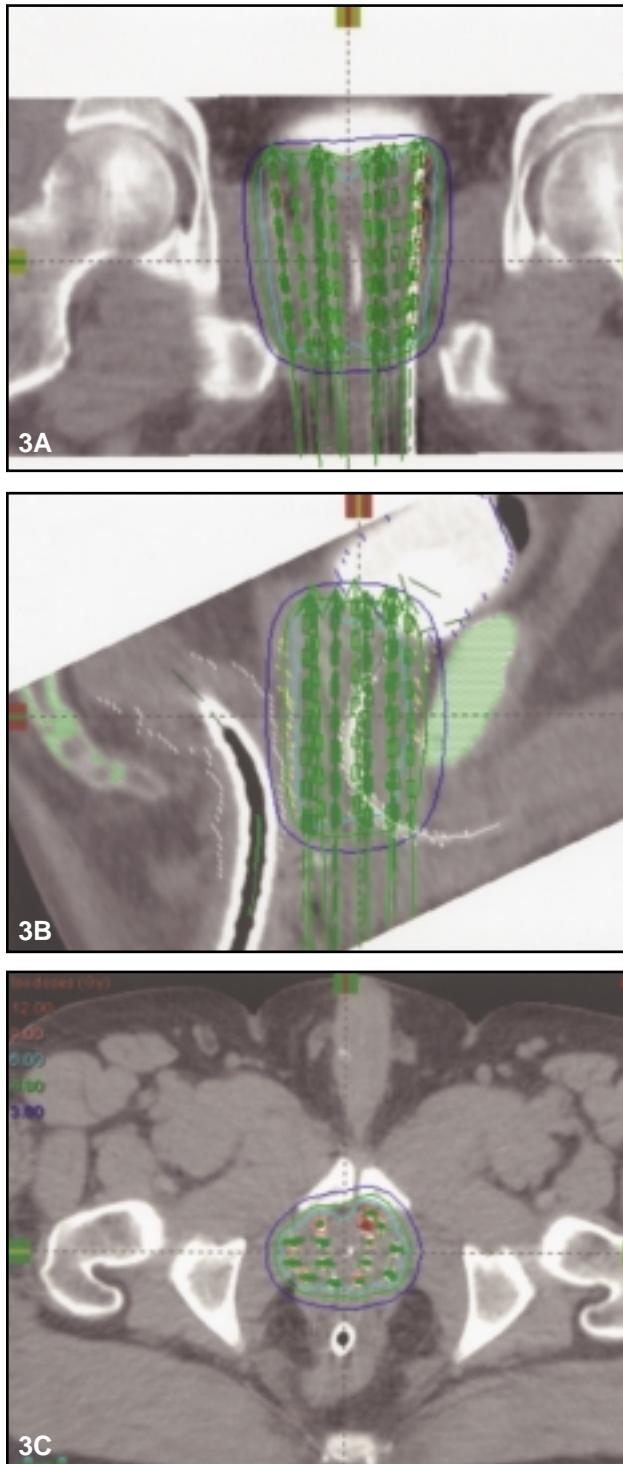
(A) AP view with isodose plots, (B) lateral view with isodose plots, and (C) CT cross section with isodose plots.
